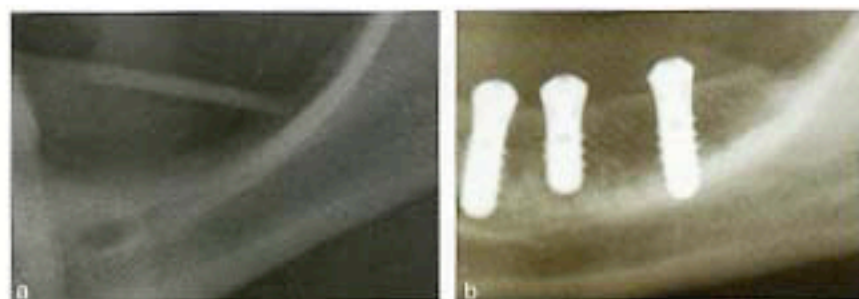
(a) Panoramic radiograph before bone augmentation. Minimal bone height over the mandibular canal. (b) Panoramic radiograph after implant surgery. Vertical bone gain of approx. 8 mm.
